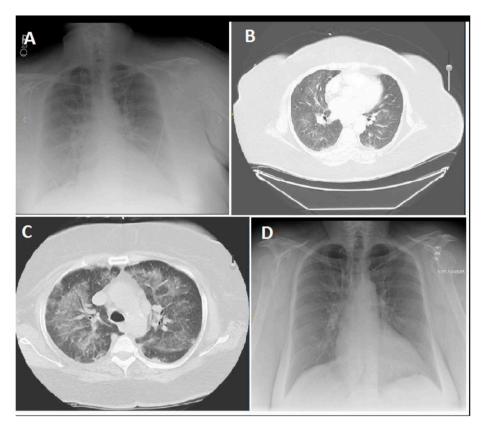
Serial radiographic Imaging.
